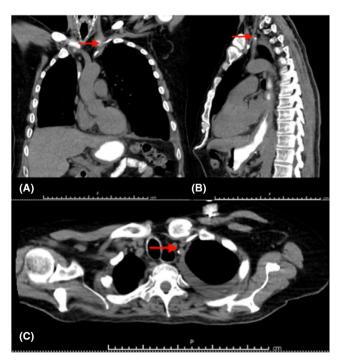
Noncontrast CT scan with arrow indicating the internal jugular vein. A, coronal section with internal jugular vein partially obscured by the clavicle. B, axial section. C, sagittal section
